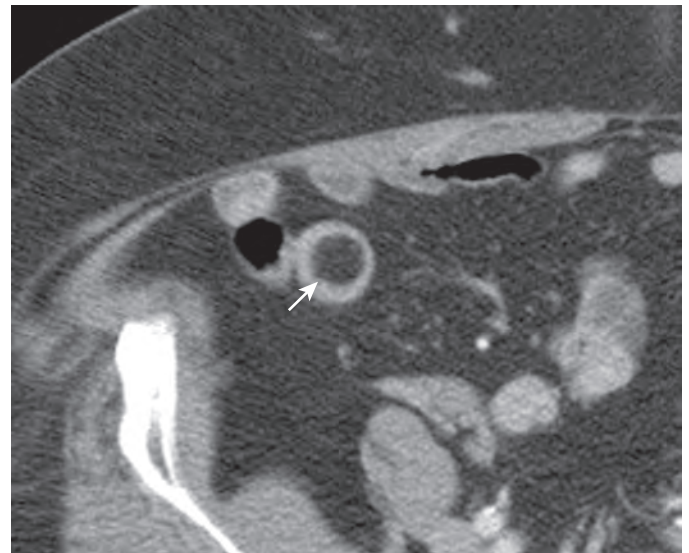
Lipoma. This CT scan shows a lipoma protruding into the bowel lumen (arrow). A well-circumscribed, intraluminal homogenous mass of negative attenuation consistent with fat is characteristic of an enteric lipoma on CT.
